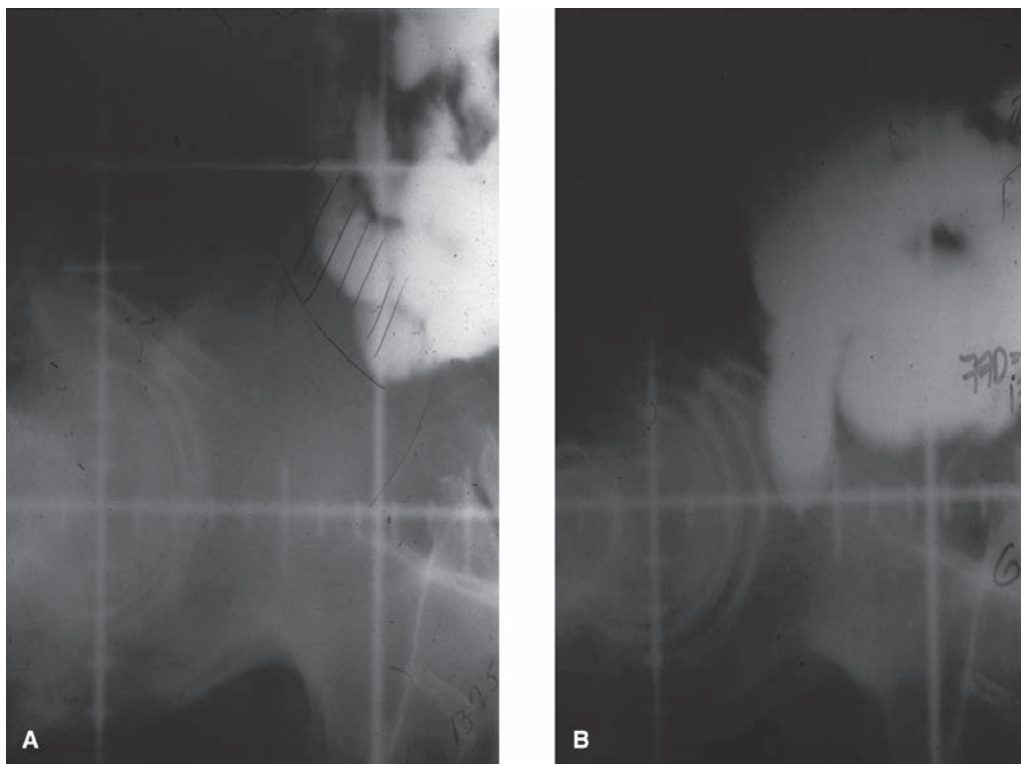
Lateral radiographs with and without bladder distention in a patient with contrast in small intestine.
